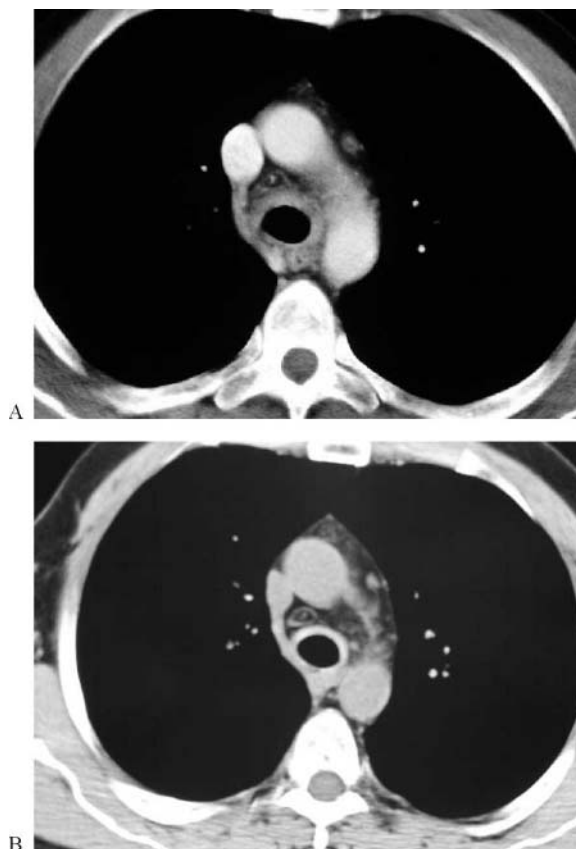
(a) Relapsing polychondritis: CT scan showing inflammatory thickening of tracheal wall. (b) Relapsing polychondritis: CT scan of same patient after treatment showing marked improvement in tracheal inflammation.
